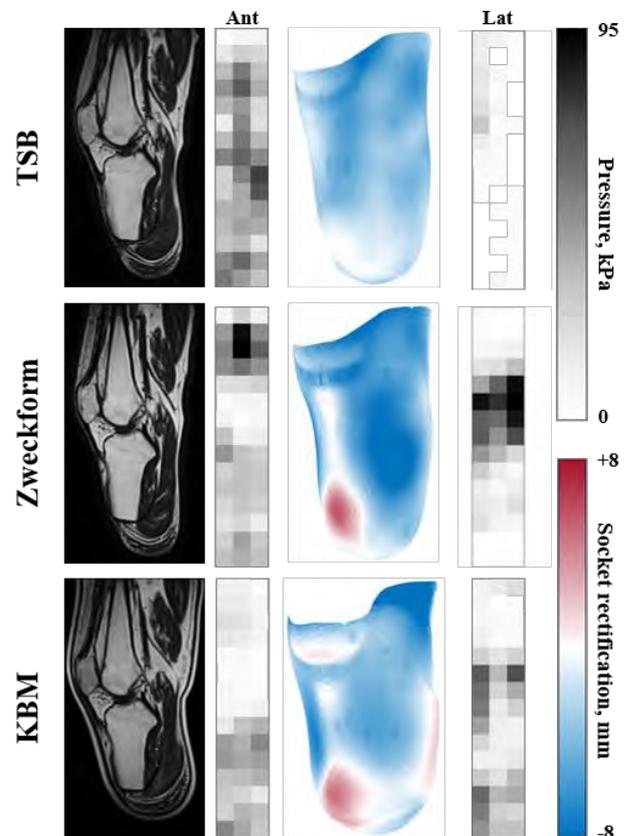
Sagittal MRI, anterior and lateral pressure distributions, and socket rectifications from 3D scanning
